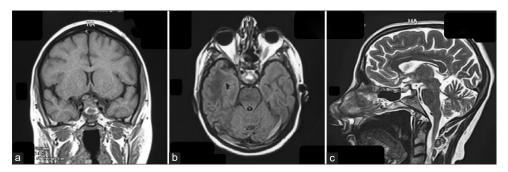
Immediate post-operative (a) T1 coronal, (b) fluid-attenuated inversion recovery (FLAIR) sequence, (c) T2 sequence. There is near complete drainage of the cyst cavity with a decompressed optic chiasm but a suspicion of small residual fluid volume present on FLAIR but not appreciable on T2.
